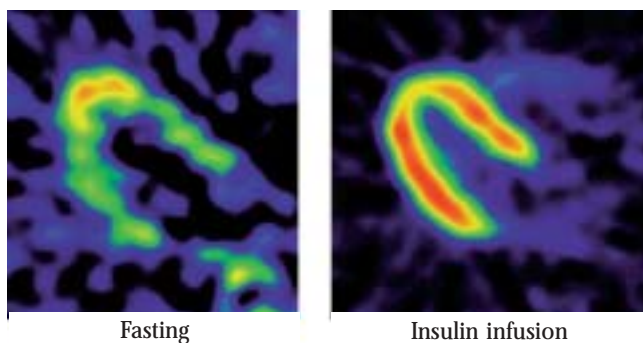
Transaxial 10 min PET images obtained 50 min after FDG injection during fasting (left) and during an insulin clamp (right). Increased FDG uptake is seen in the hibernating anterior wall during fasting but not during insulin stimulation. However, in a quantitative analysis, the hibernating anterior myocardium also responded strikingly to insulin (sixfold increase in glucose uptake). Reproduced from Mäki et al.¹¹
